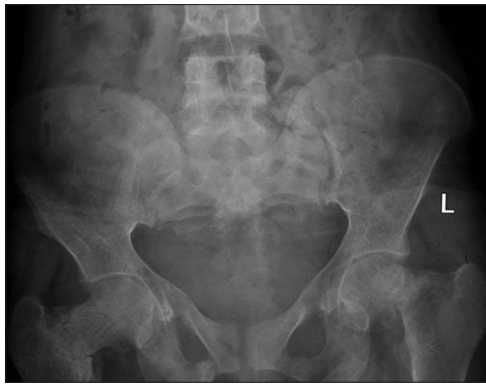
X-Ray of the hip showing pseudofracture of the right hip joint and pathological fracture of the left hip joint
